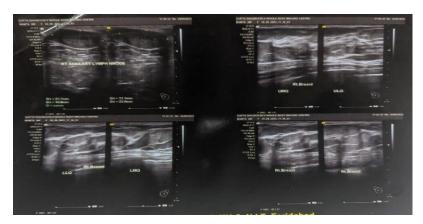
Ultrasound of axilla.
